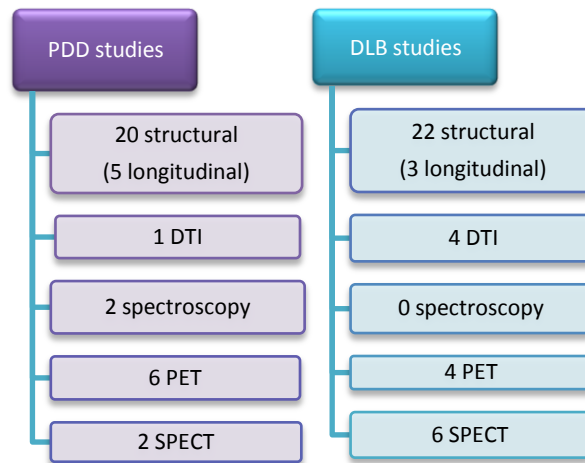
MRI studies exploring PDD and DLB patients
